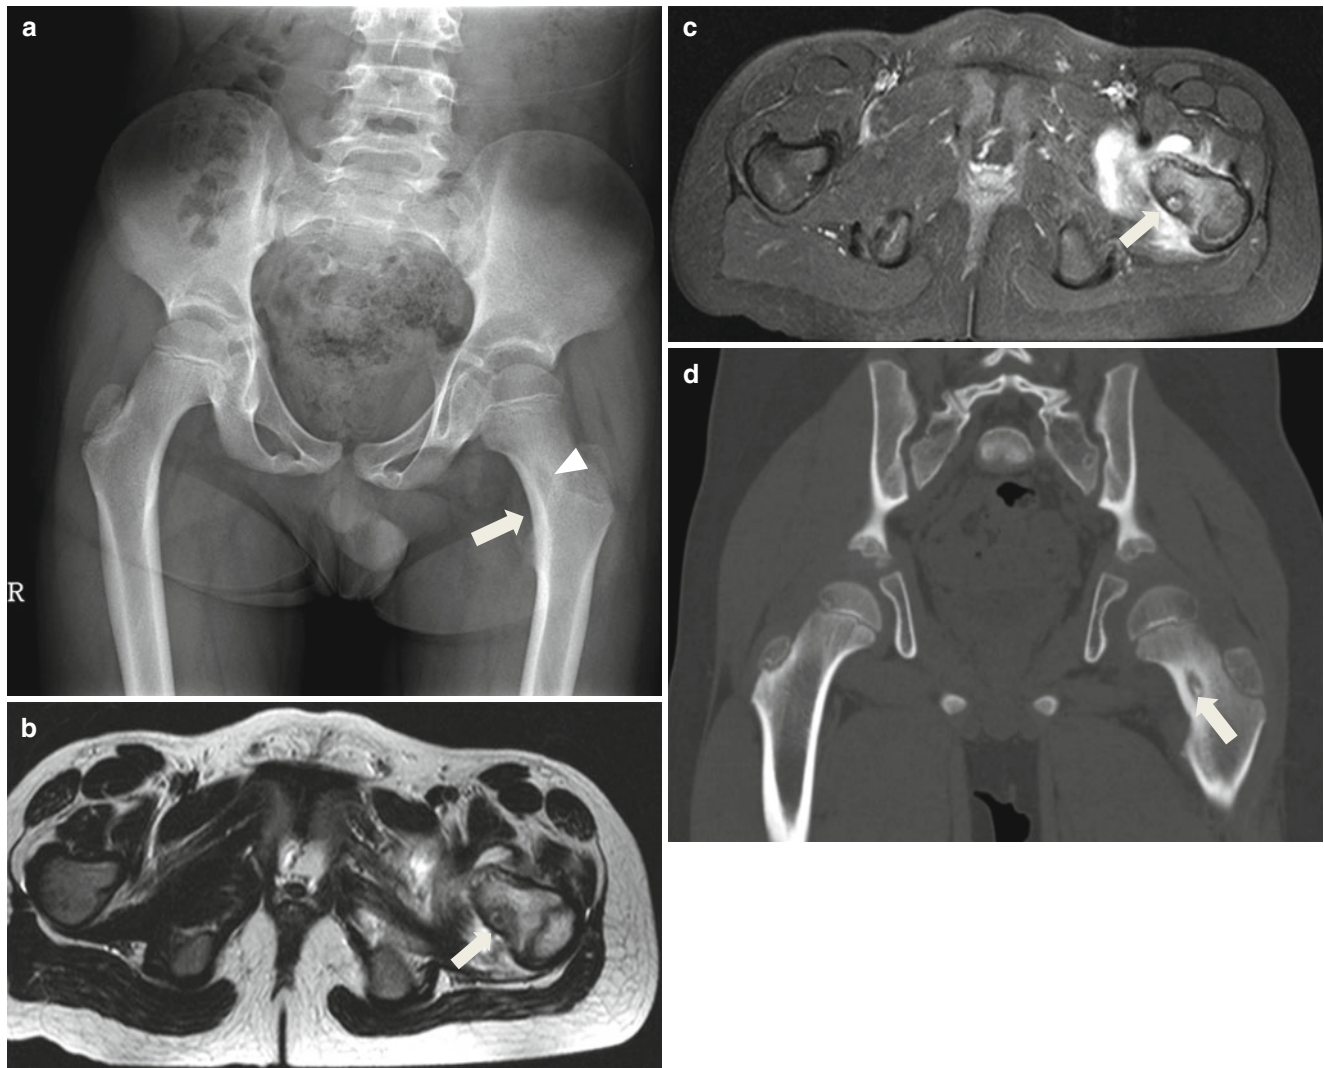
Osteoid osteoma. (a) Anteroposterior radiograph shows localized thickening of the cortex in the left proximal femur (arrows), and ill-defined osteolytic area in the left proximal femur (arrowheads). (b) Axial T2-weighted image shows a cortical-based lesion (arrow) within the femoral neck with surrounding muscle and bone marrow edema. (c) Contrast-enhanced T1-weighted image shows peripherally
